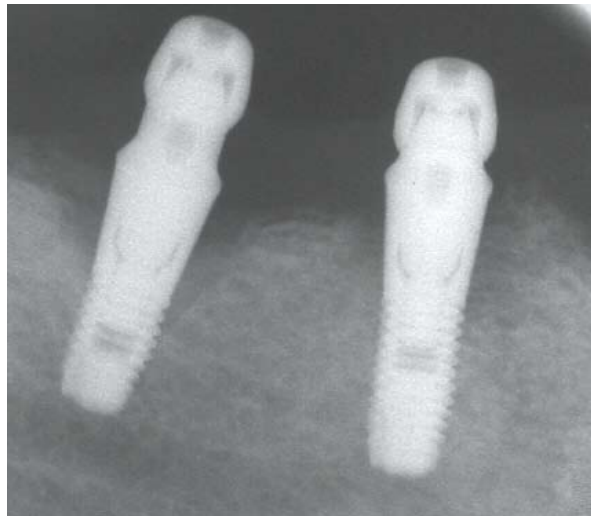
Intraoral radiography showing peri-implant circumferential bone loss.
